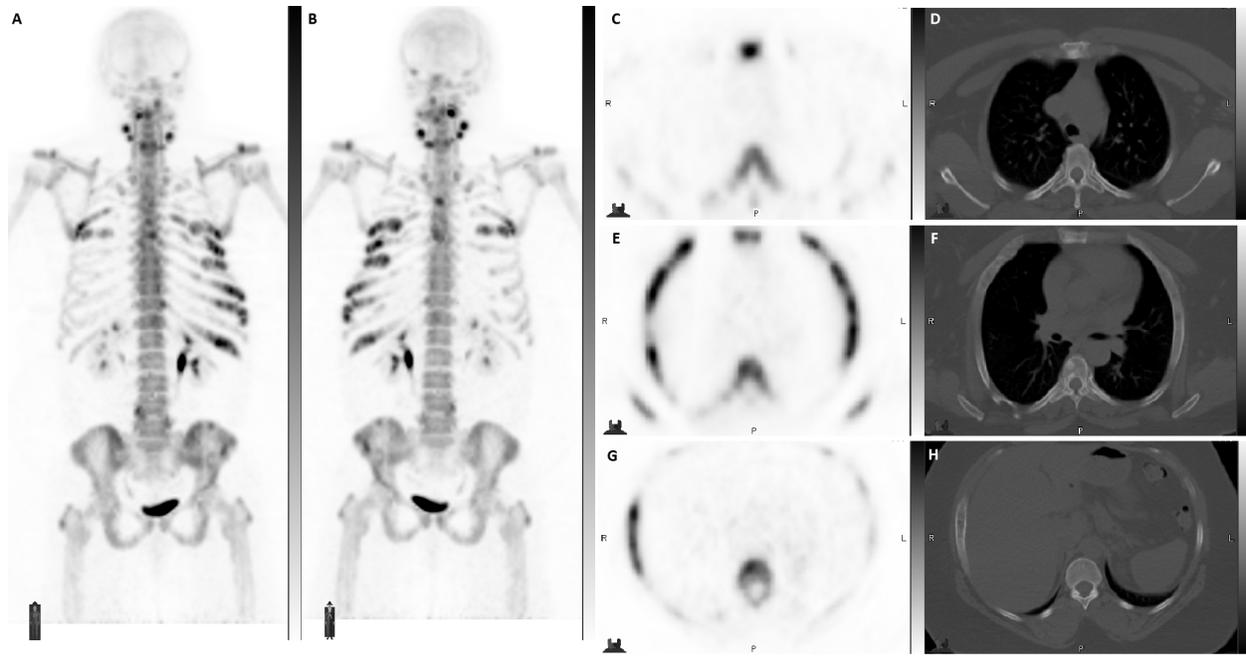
A 48-y-old women with history of plasma cell dyscrasia. (A, B) Anterior and posterior maximum intensity projection (MIP) views of the ^{18}F -NaF PET scan show multifocal area of abnormal increased tracer uptake in the spine, bilateral ribs and mandible. (C-H) Selected axial PET and CT bone window images shows expansible lesion involving bilateral ribs with ground glass density and associated abnormal tracer uptake. These lesion were stable on multiple follow-up scans and were attributable to the polyostotic fibrous dysplasia.
